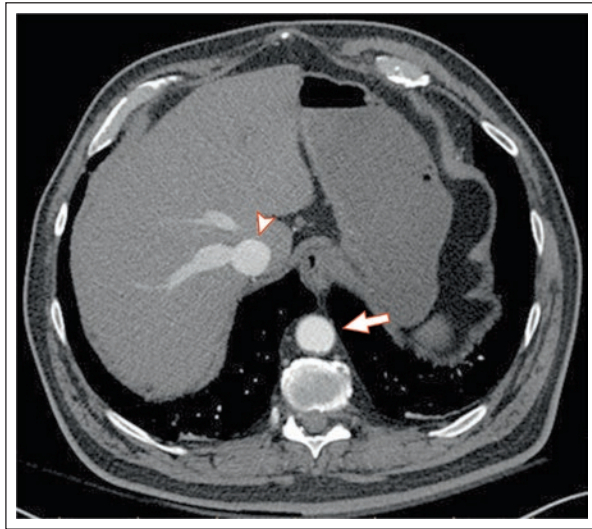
Axial arterial phase contrast-enhanced CT shows equal enhancement in the aorta (arrow) and IVC (arrowhead). The contrast medium flowing back into the hepatic veins indicates possible venous hypertension.
